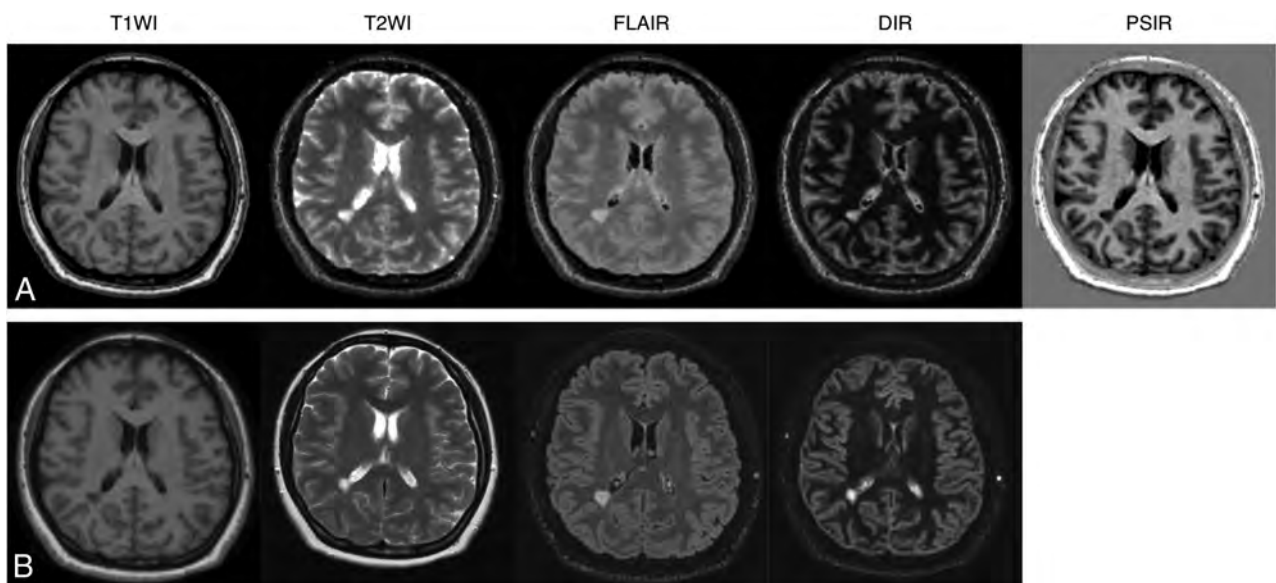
Representative examples of quantitative synthetic (A) and conventional (B) MR imaging in a 35-year-old woman with MS. The overall image quality of synthetic T1WI, T2WI, FLAIR, DIR, and PSIR were scored as 5, 3, 3, 5, and 5 by reader 1 and 5, 3, 4, 5, and 5 by reader 2. All of the conventional contrast-weighted images were scored as 5 by both readers.
